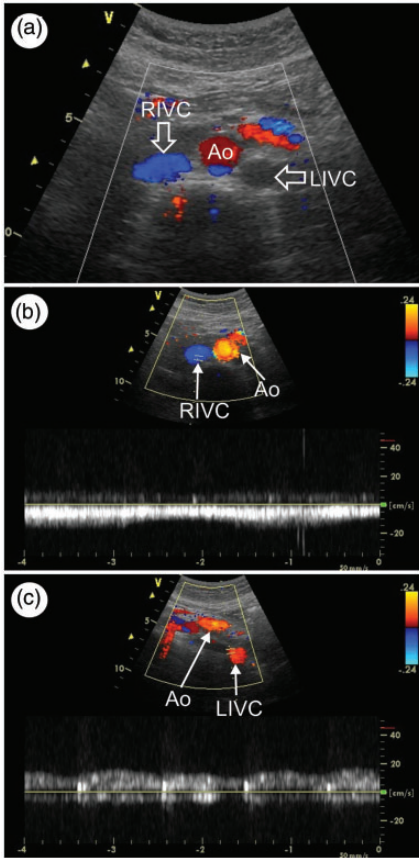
Colour Doppler ultrasonography images of the abdomen, scanned at the L2 level, showing: (a) the abdominal aorta (Ao), the right inferior vena cava (RIVC) typically located on the right side, with normal blood flow (indicated by blue colour, cranial direction), and the left inferior vena cava (LIVC) on the left side, with weaker blood flow (indicated by no visible colour change); (b) the spectrum of blood flow velocity of the typical RIVC (blue colour, cranial direction), and opposite blood flow direction of the Ao (red colour, caudal direction); and (c) the spectrum of blood flow velocity in the atypical LIVC (red colour, caudal direction, similar to the Ao).
